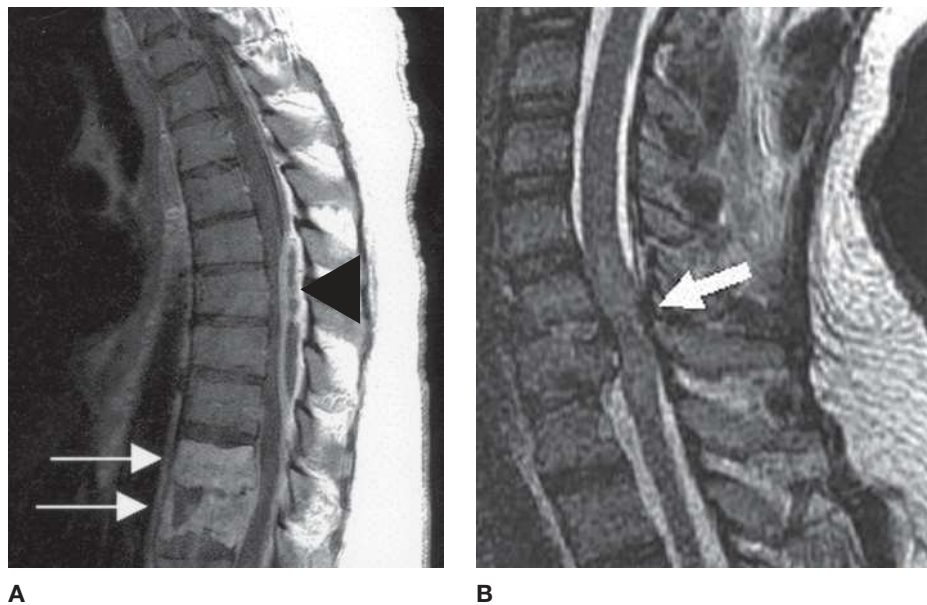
Spinal cord compression. (A) Sagittal postcontrast MRI shows diskitis/osteomyelitis (arrows) and a rim-enhancing epidural abscess (arrowhead) compressing the spinal cord. (B) Sagittal T2-weighted MRI in another patient shows a traumatic fracture at C6–C7 compressing the spinal cord. Note the abnormally high signal within the spinal cord (arrow).
